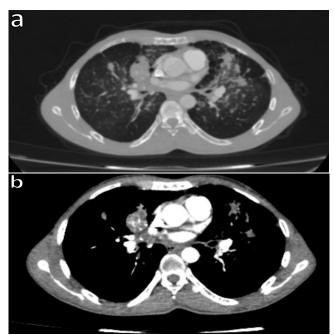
Bilateral multiple tumorlet foci and peripheral carcinoid tumors are observed in the chest angiography CT of the patient, who was presented to the emergency department with sudden hemoptysis. No bronchiectasis (a-b)
